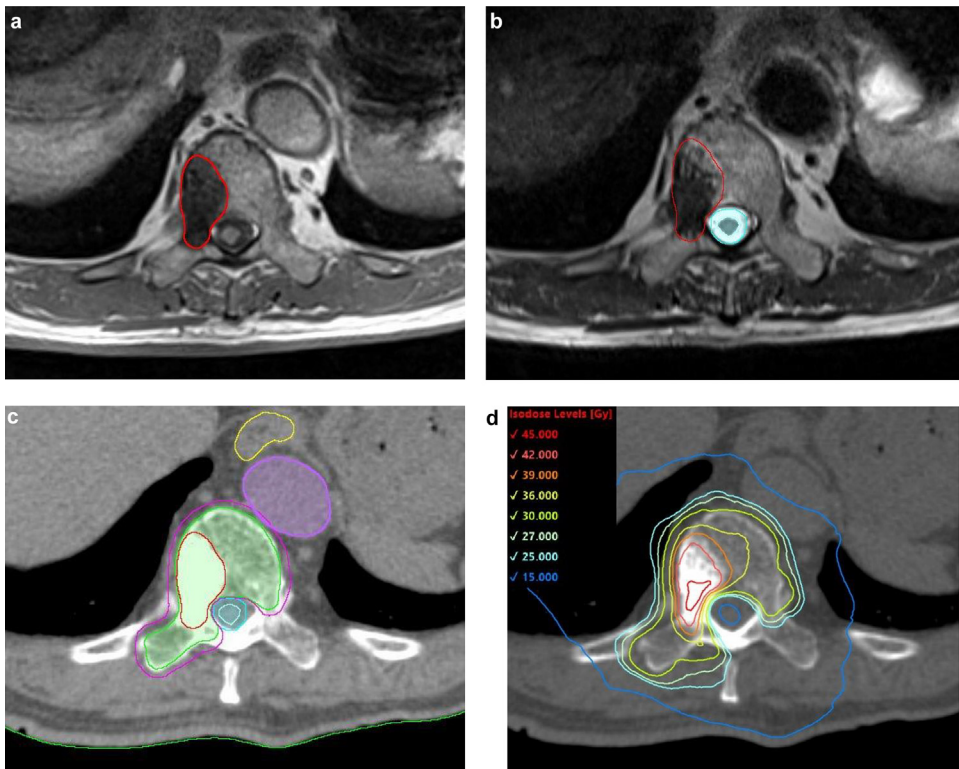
(a) Axial T1-weighted MRI with GTV (red). (b) Axial T2-weighted MRI with spinal cord and SpinalCord_PRV02 contours (light blue). (c) Axial CT images with CTV (yellow-green), PTV_Eval (pink), and organs at risk. (d) Axial CT images with dose distribution of SIB–SBRT.
